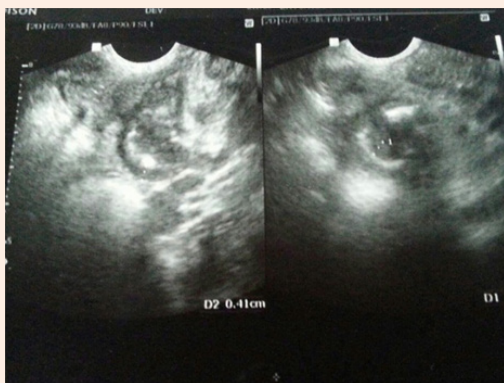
An ultrasound showing, bowel wall thickening with mesenteric lymphadenopathy in the right iliac fossa. The thickened bowel loops showing an angulated intraluminal focus? foreign body.
